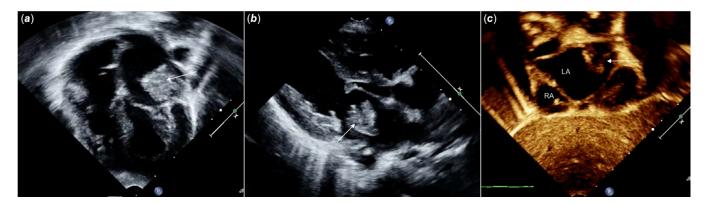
Echocardiographic images of patient 1. (a) Four-chamber view showing a large echogenic mass (white arrow) attached to the lateral wall of left atrium just above the mitral valve. (b) Parasternal long-axis view showing the echogenic mass in left atrium. (c) Subcostal long-axis view showing inverted left atrial appendage (white arrow). Note the continuity of the structure with left atrial wall. LA=left atrium, RA=right atrium.
